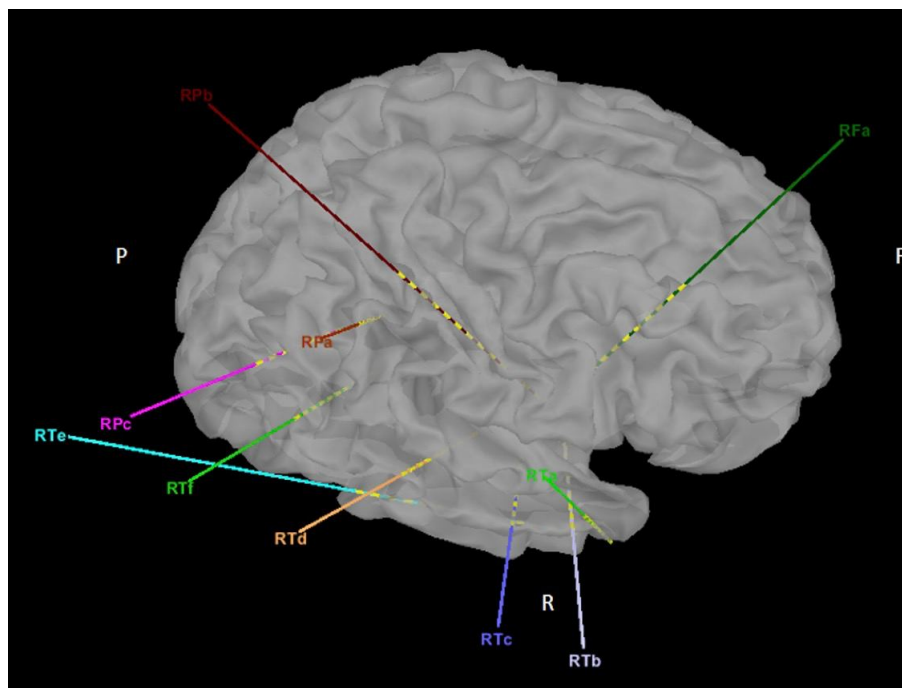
Cortical reconstruction from MRI of the patient №8.
